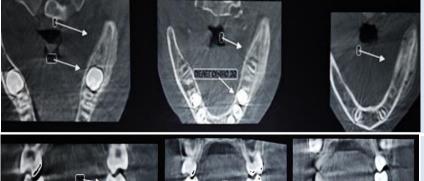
Axial section CBCT view showing expansion of both the buccal and lingual cortical plates
